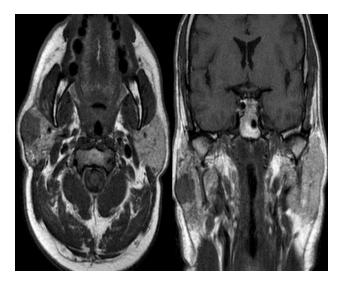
Parotid MRI, T1, axial and coronal sections.
